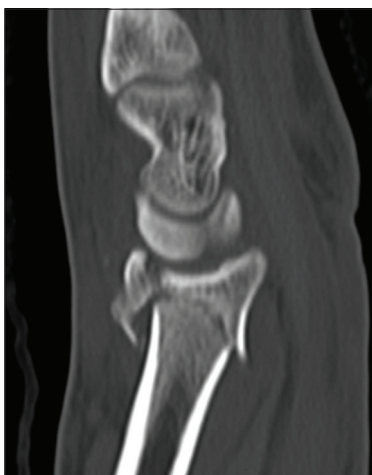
Pre-operative computed tomography scan (sagittal view) showing a fractured dorsal rim with small retained dorsal articular surface
